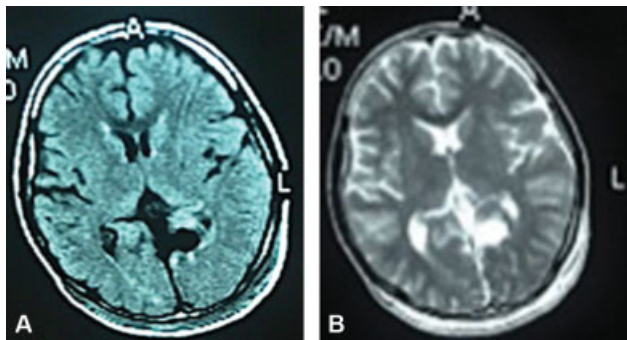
Preoperative magnetic resonance imaging studies: A,B,C (T2-gradient Echo, FLAIR, and T2 images, respectively), showing a left medial occipital cavernoma with mixed intensity core (popcorn appearance) surrounded by a hypointense hemosiderin ring, with no surrounding edema. D: Coronal view showing the proximity of CCM to the medial surface. E: Sagittal view showing the exact location of the CCM at the left lingual gyrus; red arrow: lingual gyrus, yellow arrow: cuneus, blue arrow: the cavernoma.
